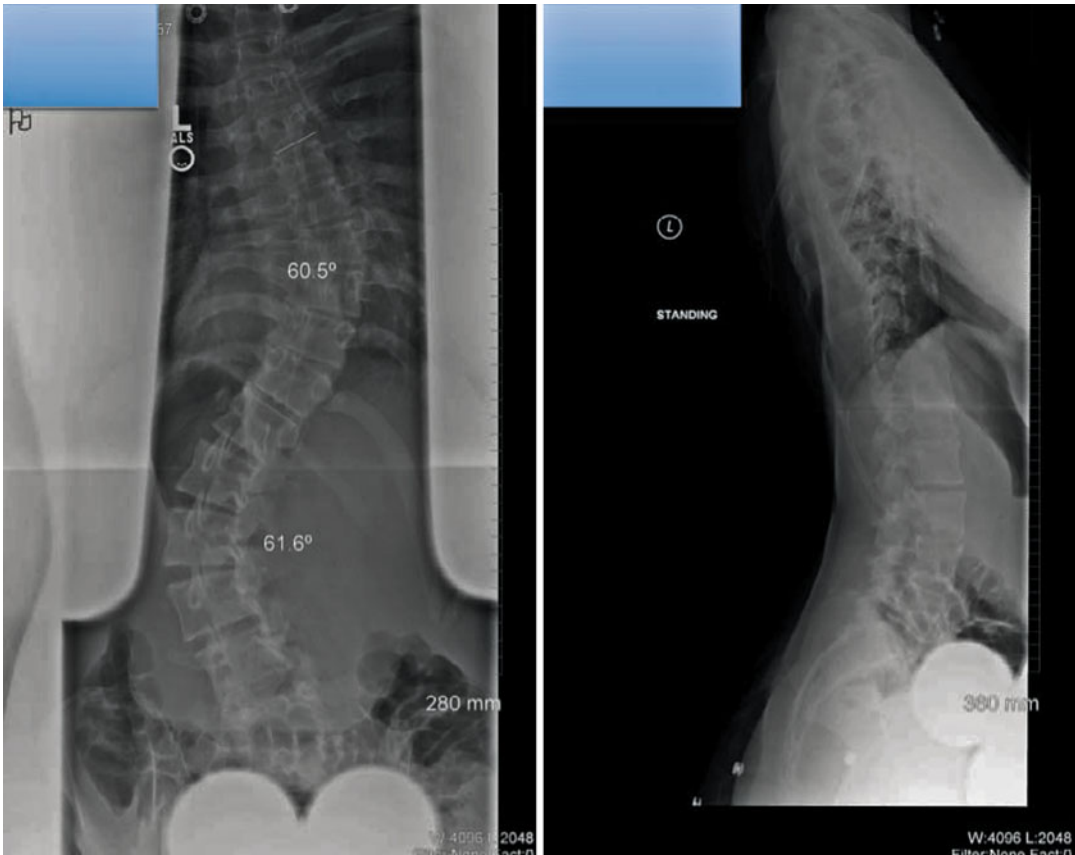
Preoperative radiographs showing double major curves and large deformity
